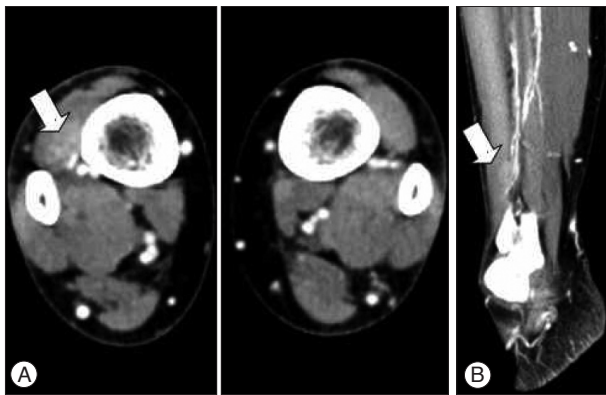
Computed tomography (CT) scan with contrast. An axial (A) and sagittal (B) cut of CT scan with contrast shows a well-defined, enhanced lesion located near to the deep peroneal nerve sensory branch. A soft tissue mass, within the sensory branch of right deep peroneal nerve, was enhanced by contrast material.
